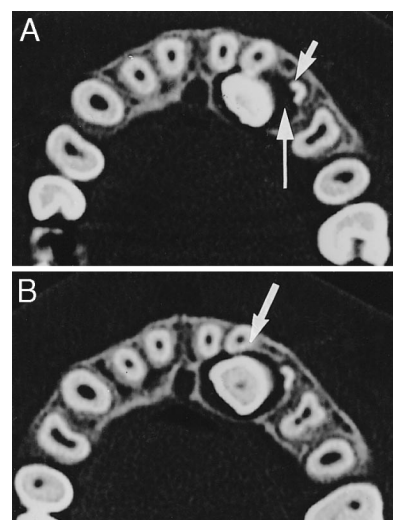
Findings in a 14-year-old boy on axial computed tomography (CT) scans. No. 23 is erupting lingually to No. 21 and No. 22. The periodontal contours of No. 21 and No. 22 facing the dental follicle of No. 23 are missing. No. 23 is in contact with the lingual aspect of No. 22, and the root has been slightly resorbed at the contact point (B, arrow). The follicle of No. 23 extends toward No. 63, and the root of No. 63 has been resorbed adjacent to the widened follicle but is intact buccally. There is a gap between No. 23 and No. 63 (A, arrow). No. 13 is erupting normally and at a distance from No. 12 and No. 14. The periodontal contours of No. 14 and No. 12 are unbroken.
